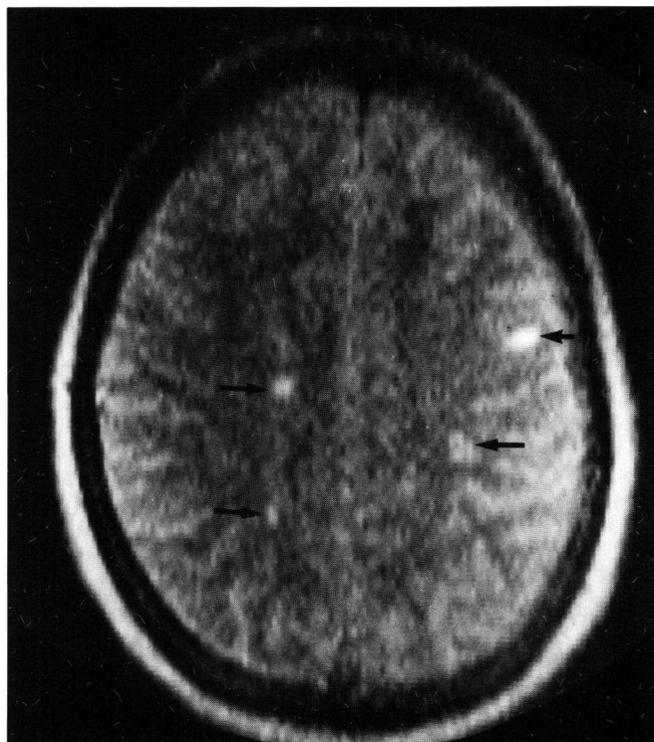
Transverse supraventricular MR image obtained by the multislice multiecho SE technique (TE = 60, 120; TR = 2040) at one year revealed four foci of increased signal intensity in the white matter (arrows). These changes are consistent with the diagnosis of multiple sclerosis.
